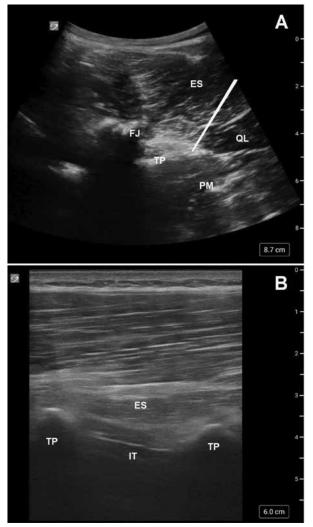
A) Ultrasound image and landmarks of a lumbar ESPB in axial orientation with proposed ideal needle (white) placement on lateral tip of TP; ultrasound indicator is medial. B) Ultrasound image and landmarks of a lumbar ESPB in sagittal orientation; indicator is cephalad.
